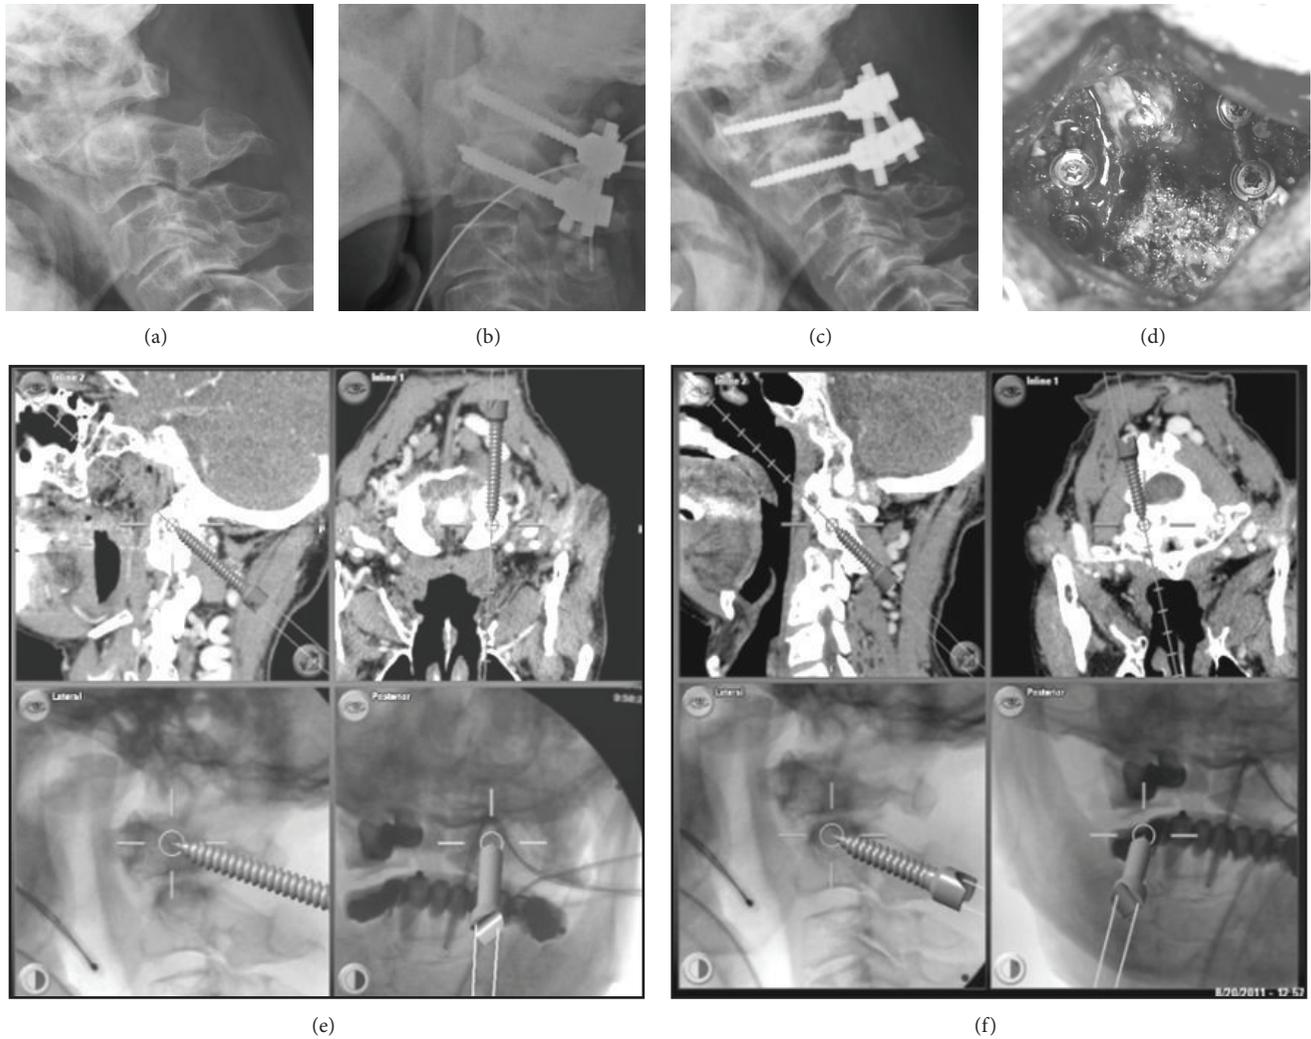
Preop lateral radiograph revealed AAI (a). Postop radiographs revealed fixation after operation ((b) and (c)). The operative photo showed LC1-PC2 system (d). The intraoperative CT navigation guided technique for placement screw for C1 (e) and C2 (f).
